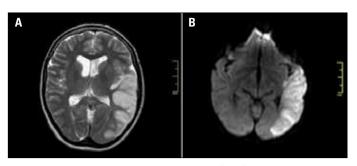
A, B. Magnetic resonance imaging (MRI) demonstrated signal abnormalities in left cortical and subcortical regions (panel A). Diffusion MRI showed impaired diffusion in the same regions with 3x9 cm in dimension (panel B)
